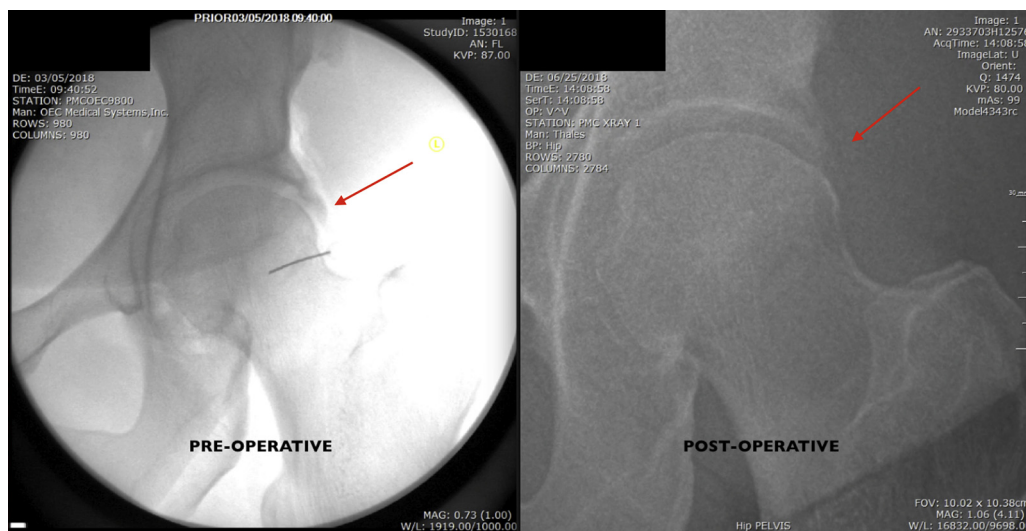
Anteroposterior fluoroscopic view of a left hip showing an ossified labrum (left), incapable of providing adequate suction seal and indicated for reconstruction, and postoperative radiograph showing removal of ossified labrum (right). A 5.5-mm arthroscopic burr is used to address the acetabular pincer morphology.
